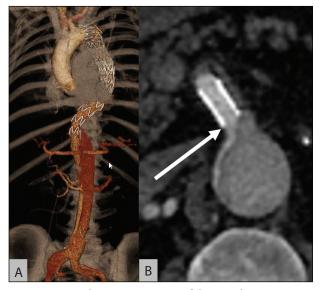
Control 3D reconstruction of the CTA showing correct placement of the thoracic endograft and mesenteric perfusion but persistent TL compression in the abdominal aorta (A). Axial CTA showing correct stent placement and mesenteric perfusion but persistent TL compression below (B).
